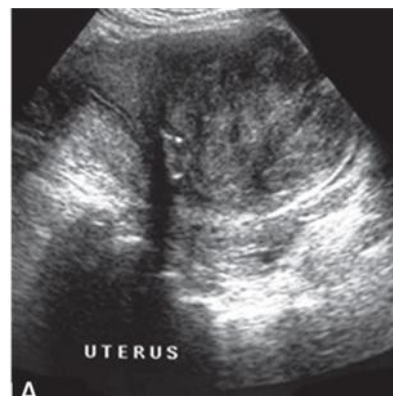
Pelvic ultrasonogram showing a heterogeneously hypoechoic lesion that measures 15X11 cm seen in the posterior myometrium (left lateral aspect) indenting and displacing endometrial echo. No definite hyperechoic foci to suggest calcification are seen within the lesion.
